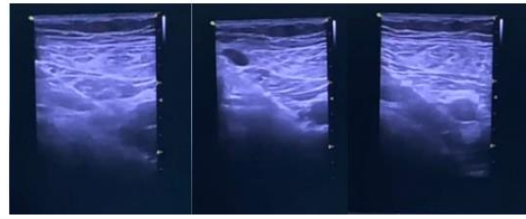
Ultrasound-Guided Images during Anesthesia Administration
